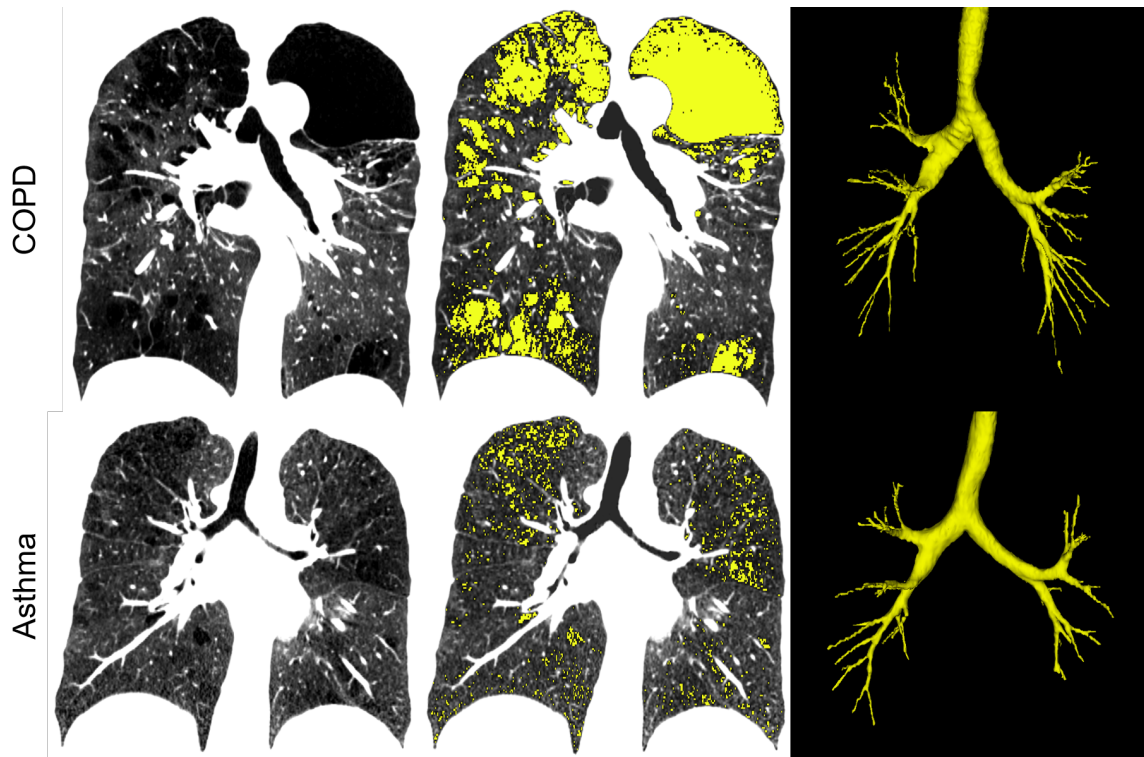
Computed Tomography of COPD and Asthma
